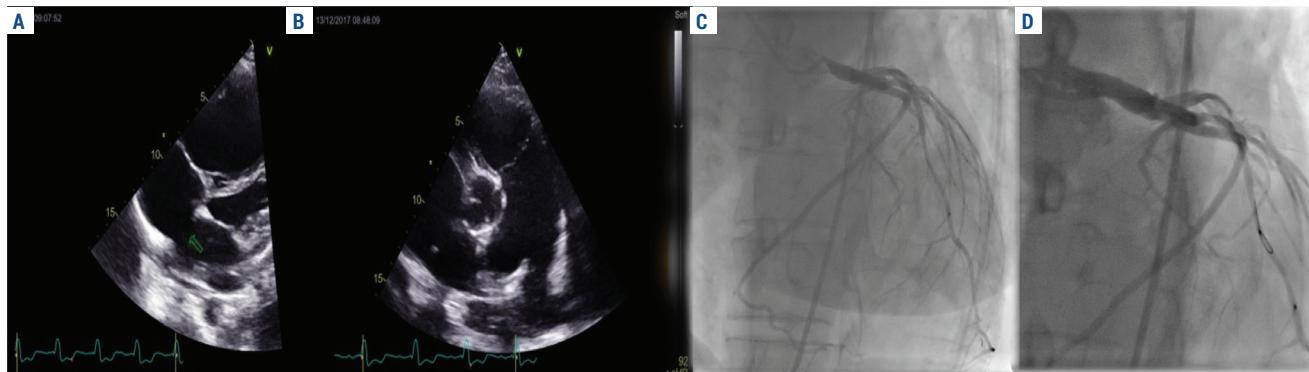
Transthoracic echocardiography of a patient with atrial septal defect, showing interatrial communication (A) and the dilated pulmonary artery (B), as well as coronary angiography of the left coronary artery before and after LMCA stenting (C, D).
